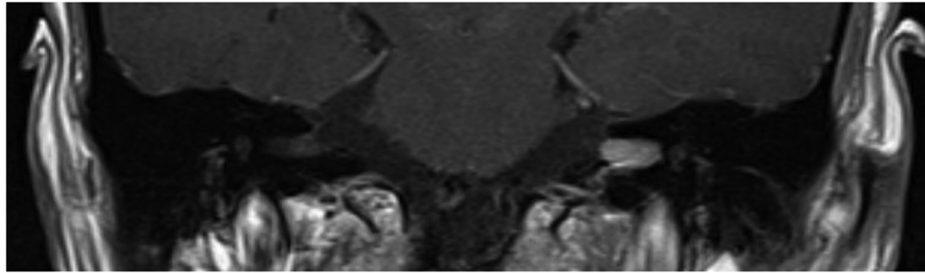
Coronal T1-weighted magnetic resonance imaging scan with contrast enhancement of a T1 vestibular schwannoma.
